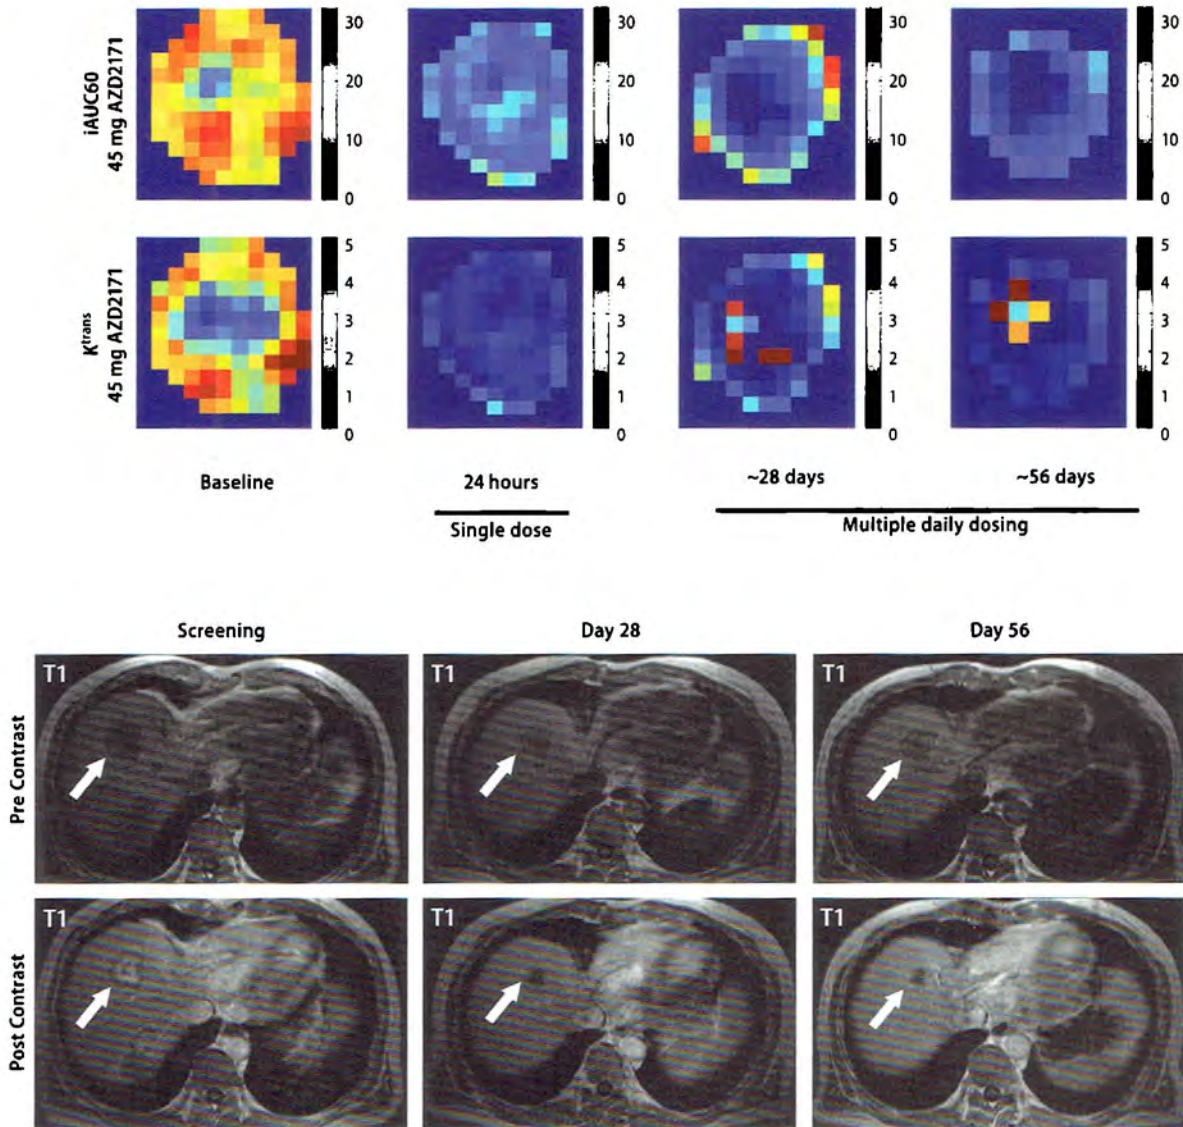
Top:* Example of DCE-MRI parametric images of tumour $iAUC_{60}$ and K^{trans} after single (24 h, day 2) and multiple daily dosing (28 and 56 days) with AZD2171. *Bottom:* Corresponding T1-weighted pre- and post-contrast MRI scans. This patient with prostate cancer experienced a best overall response of partial response and had overall tumour reductions in $iAUC_{60}$ (68% reduction at 24 h, 73% at 28 days and 84% at 56 days) and K^{trans} (67% reduction at 24 h, 83% at 28 days and 95% at 56 days) (Drevs et al. 2007)
